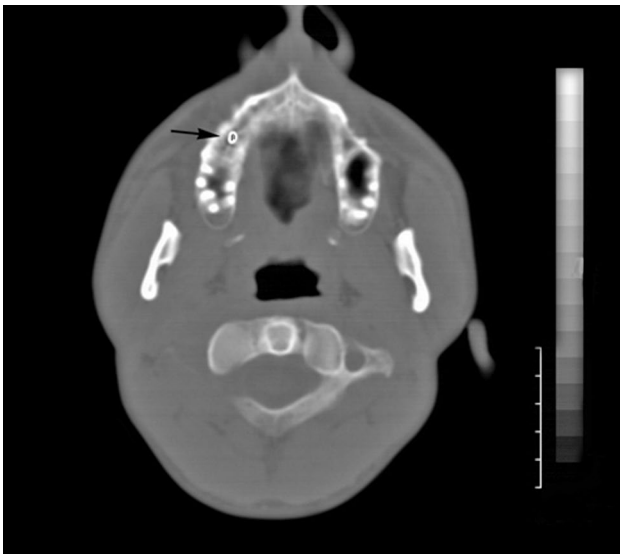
Metal foreign bodies (heads of two nails) in right posterior premolar tooth root seen on axial section paranasal sinus computed tomography scan (black arrow).
